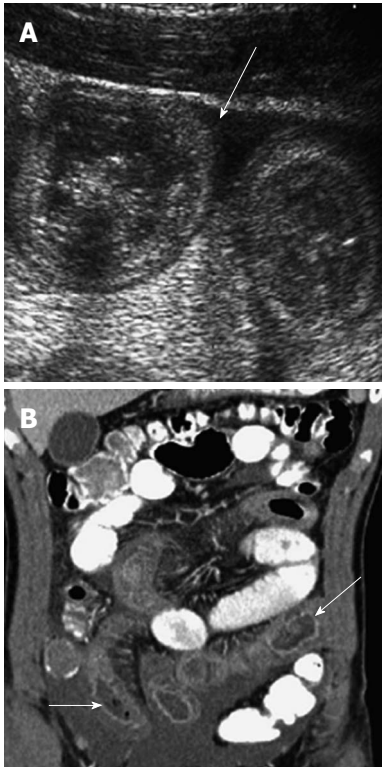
Henoch-Schonlein purpura. A: Sagittal ultrasound image shows more moderate wall thickening of small bowel with ascites; B: Coronal computed tomography shows long segments of thickened, enhancing, fluid filled small bowel (arrows).
